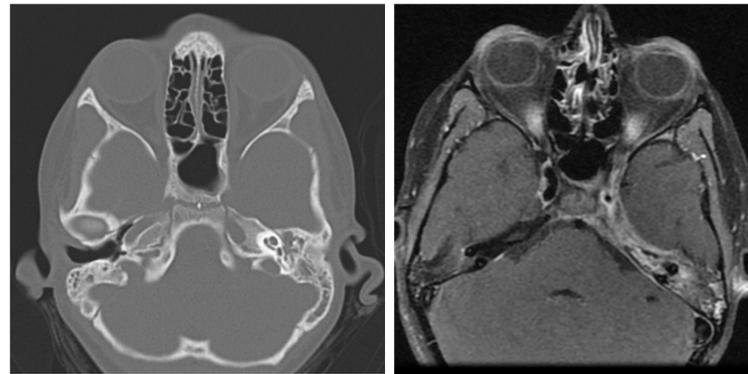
(a) Non-contrast CT scan showing complete opacification of bilateral mastoid sinuses and severe opacification of left middle ear cavity (b) T1 MRI with contrast showing soft tissue enhancement extending from cavernous sinus to left petrous apex as well as abnormal dural enhancement along medial left temporal convexity and left tentorium
